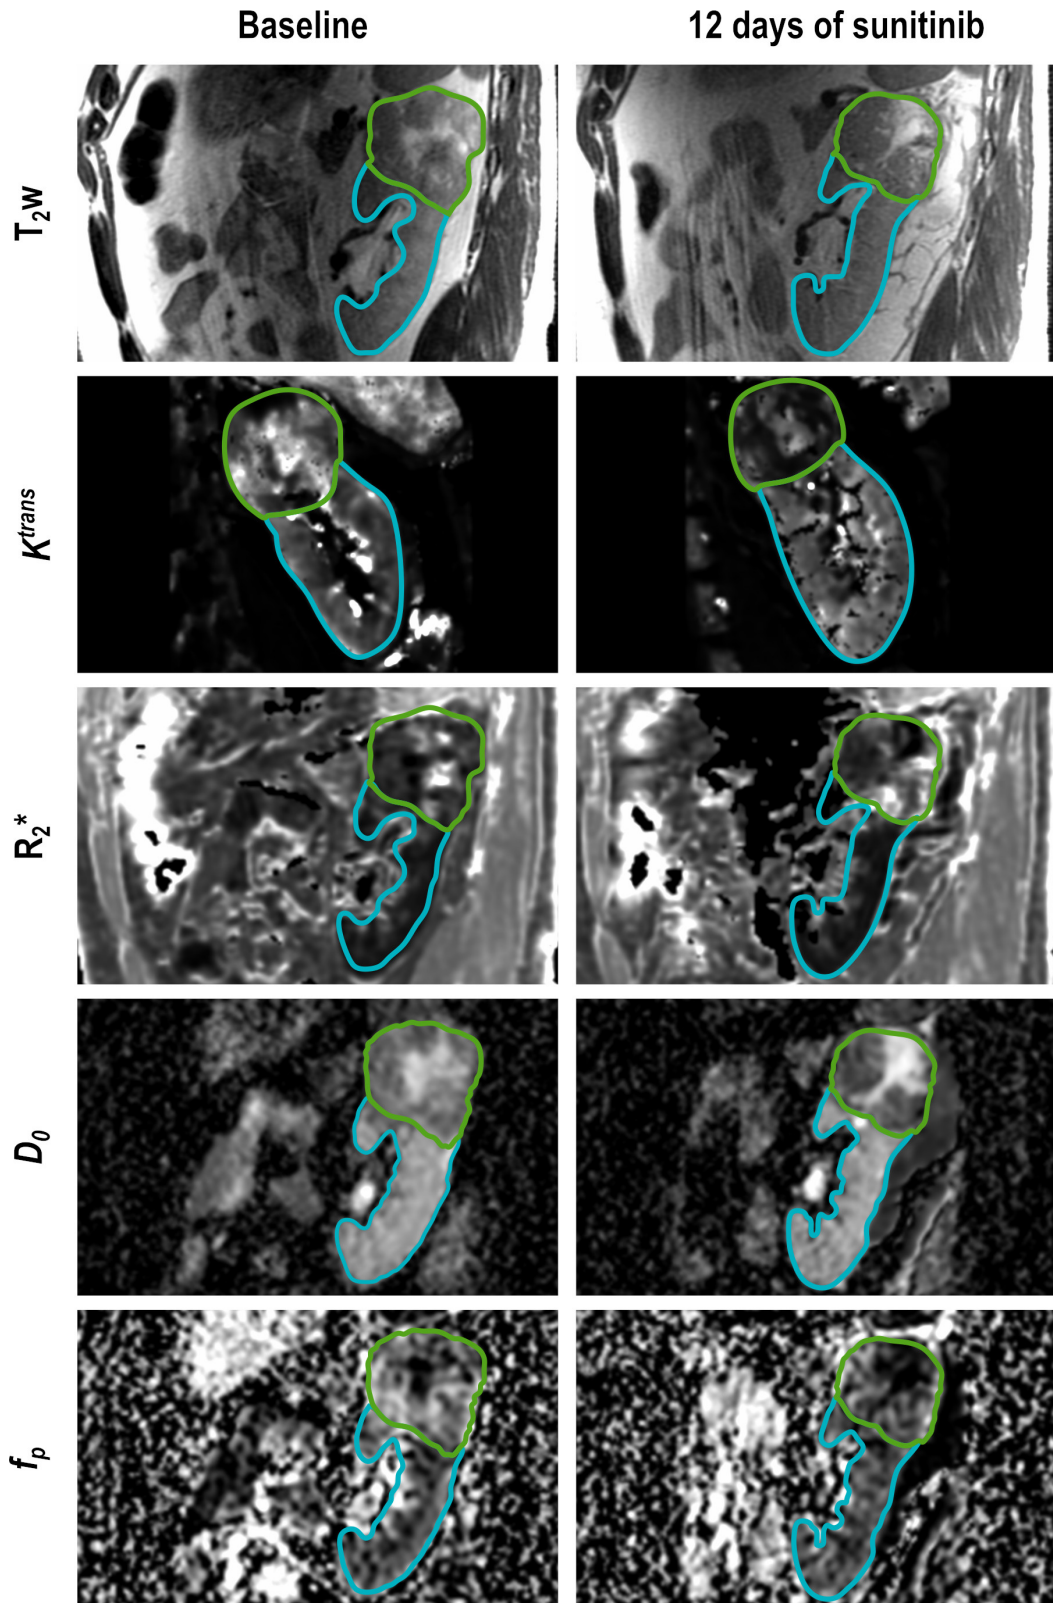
Example of physiological MRI maps of a patient in NeoSun. A reduction in K^{trans} , D_0 and f_p is apparent following treatment while R_2^* was increased in this patient. See text for an explanation of the imaging parameters.
